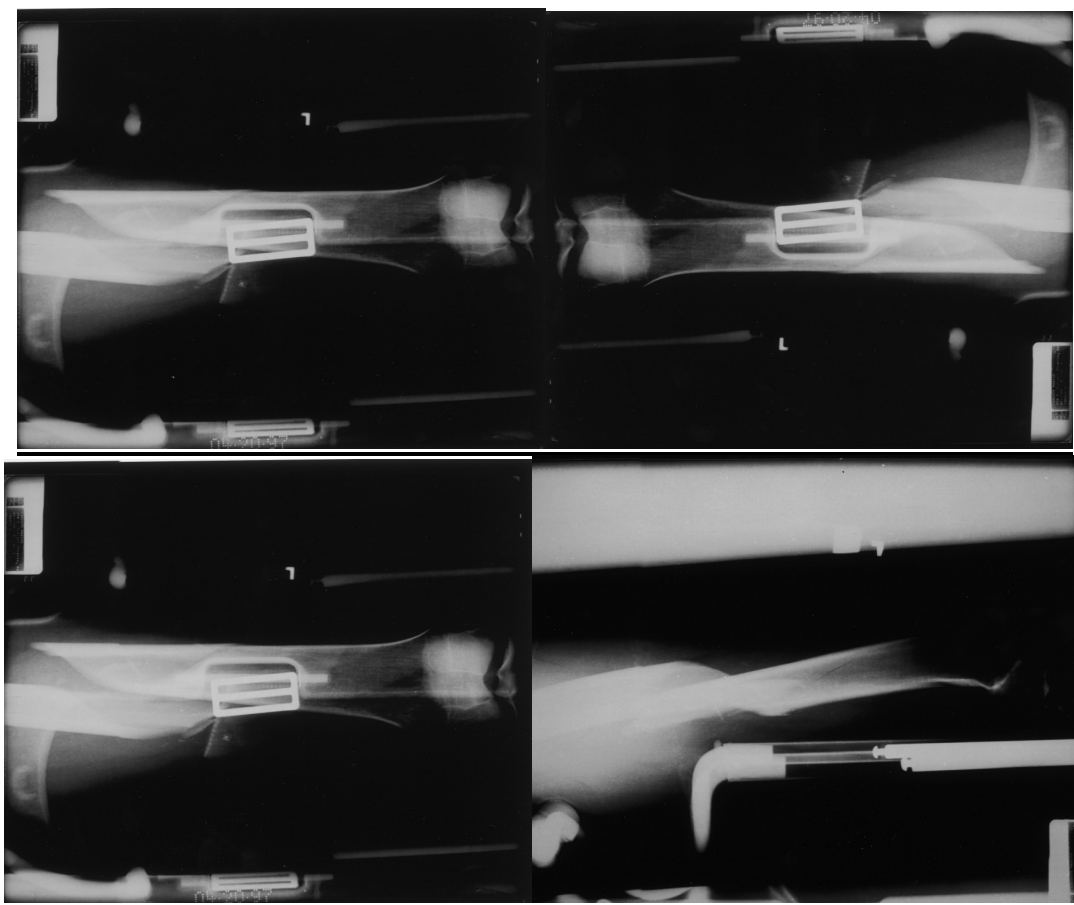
Radiographs from PWC File 25.
